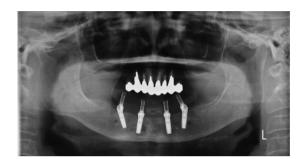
Panoramic radiograph taken after implant placement (patient 1).
